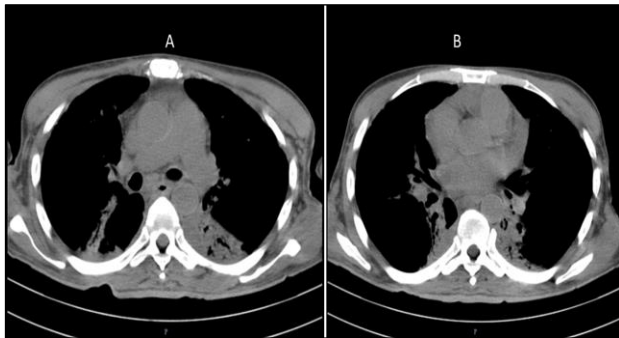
CT thorax axial window showing segmental collapse, fibrosis and bronchiectasis.
